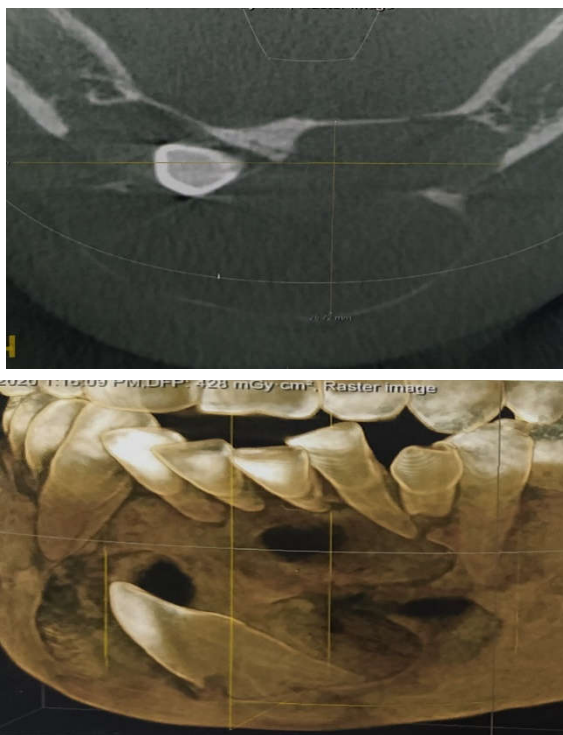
Axial and coronal section of computed tomography showing extend of lesion.
